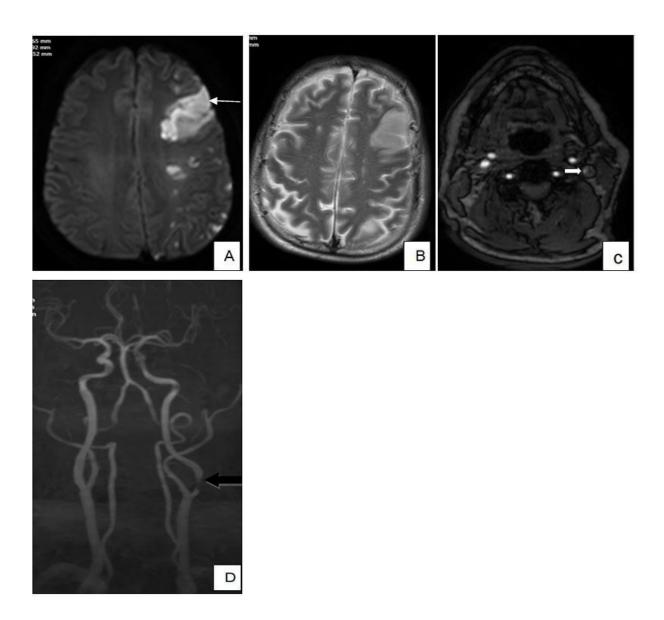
1 A 62-year-old male COVID patient, who came with altered sensorium to the ED, had multifocal acute infarcts in left frontoparietal lobes with demonstrable narrowing of the ipsilateral ICA at its origin. Fig X depicts: [A], hyperintensities on DWI images in left front parietal lobes (white arrow) with corresponding T2W hyperintensities in image [B], Absent signal intensity (due to plaques/thrombosis) in ipsilateral left proximal ICA after its bifurcation with ~90% luminal narrowing (thick white and black arrows) resulting in infarcts in left frontoparietal lobes.
